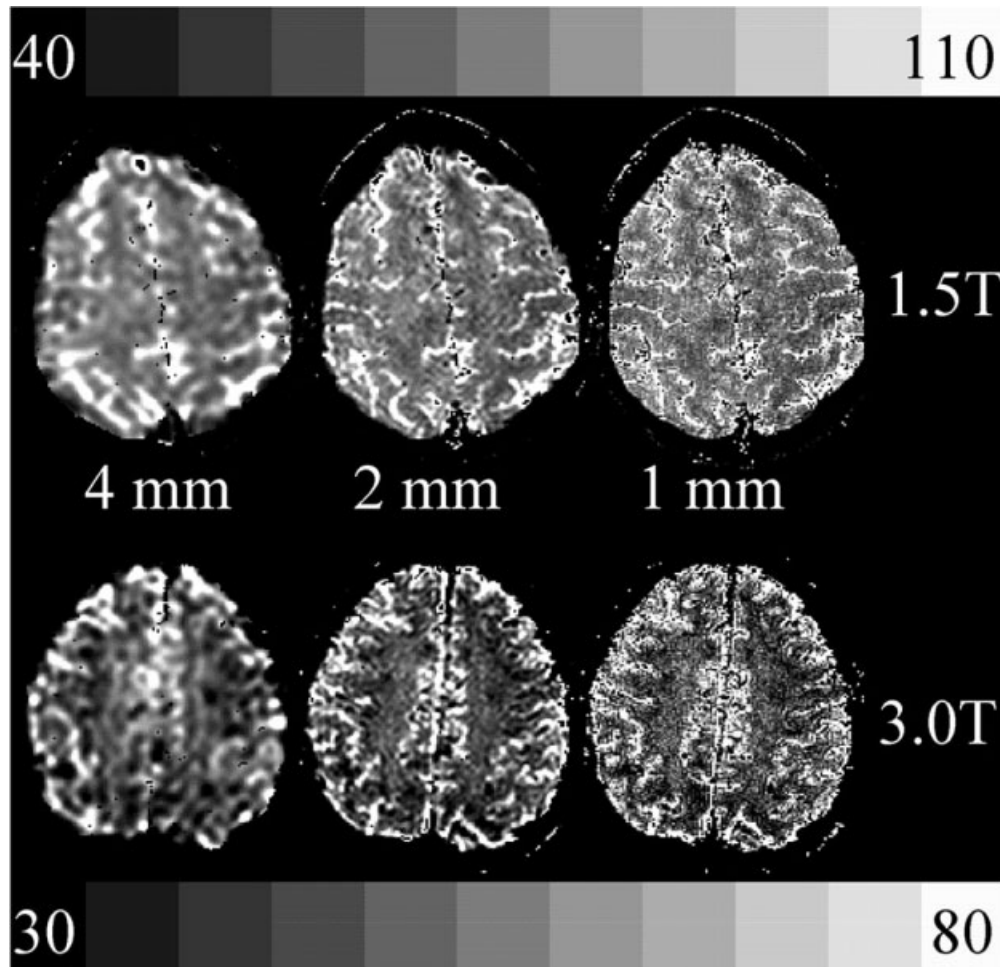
Dependence of T_2^* on resolution. T_2^* maps were calculated at 4, 2, and 1 mm (cubic) resolution from gradient echo MRI data in superior brain. Global T_2^* values do not dramatically increase at higher resolution. At 3.0 T, the 4 mm resolution data shows more distinct local dark spots, attributed to macroscopic susceptibility effects.
